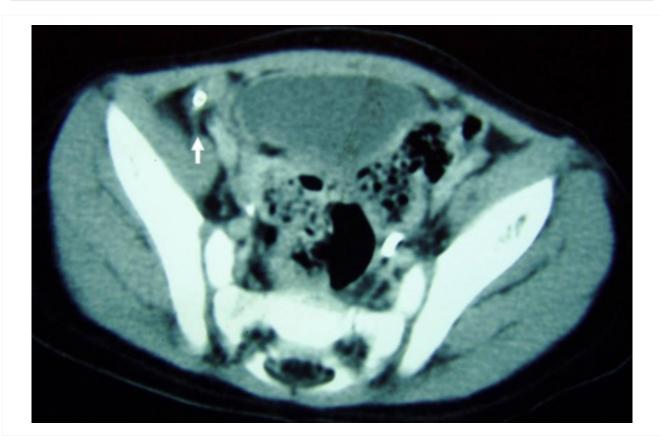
CT scan demonstrating faecalith (white arrow) outside the lumen of the appendix consistent with perforated appendix
